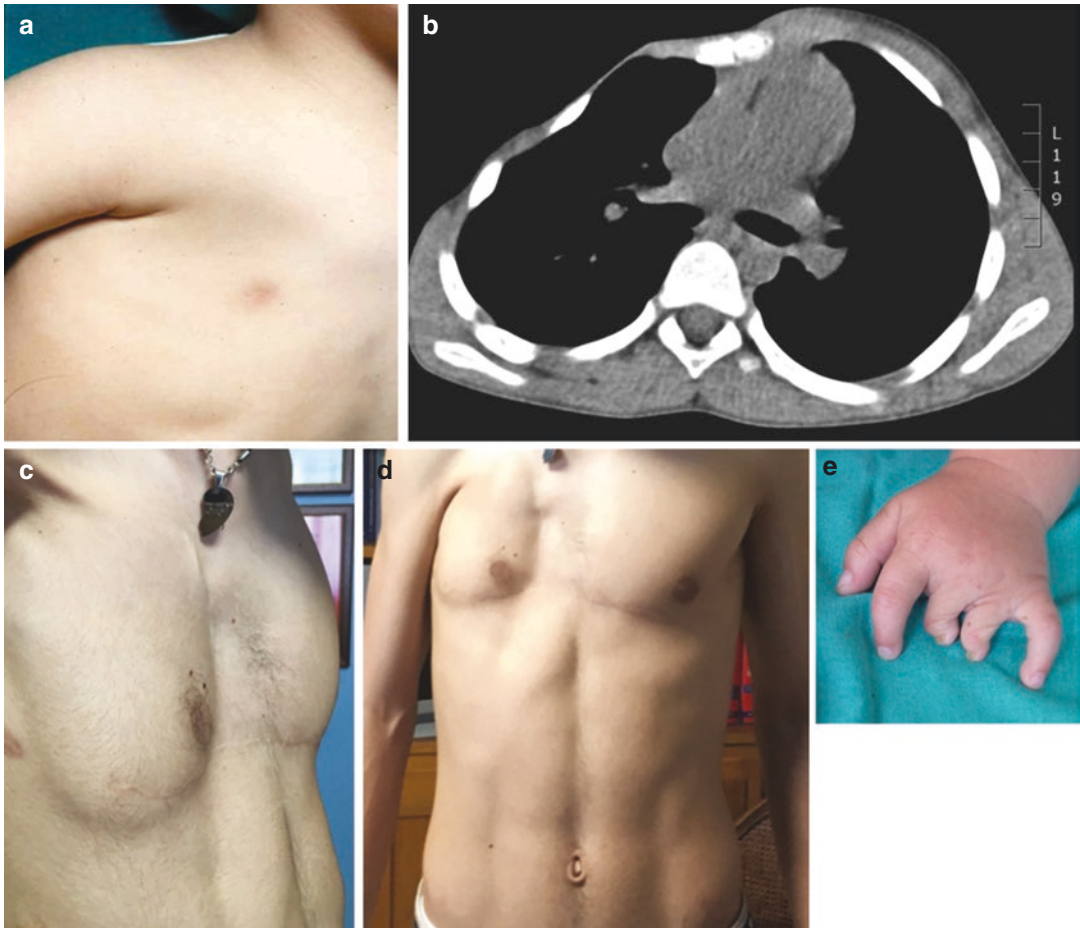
Poland syndrome: chest wall asymmetry in a patient with right form (a); CT picture of a right PS (b); postoperative pictures of the same patient at long-term follow-up (c, d); brachydactyly in PS (e)
